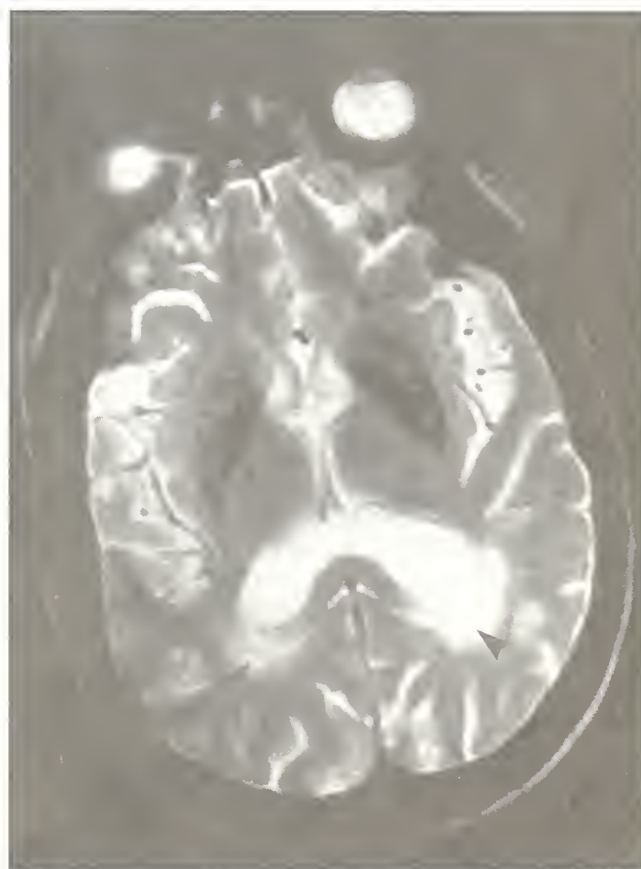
Forty-five-year-old man with CNS CMV proven by autopsy. Axial T2-weighted image revealing abnormal increased signal in the periventricular white matter (arrows).
